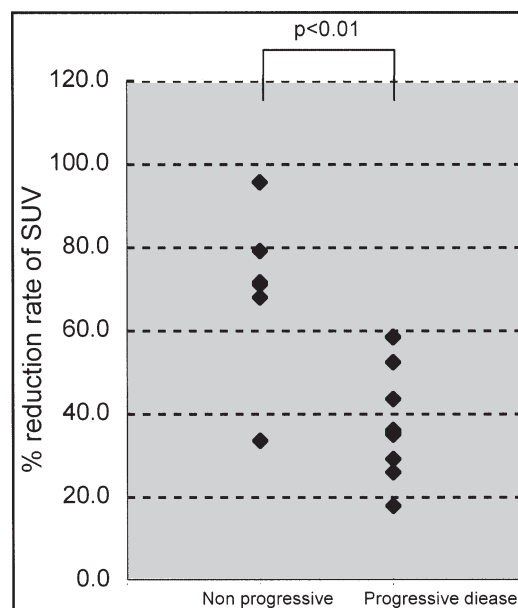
Percent reduction in SUV for nodules categorized as nonprogressive vs. progressive disease at ≥ 6 months post-RFA. The percent reduction in SUV at 2 months was significant compared with at ≥ 6 months post-RFA. Data are mean \pm SD.
